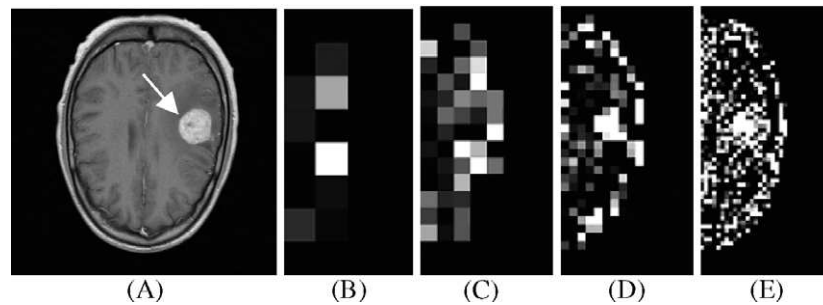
(A) T1 MR image with contrast agent. Also shown are negative FD difference results for (B) Blnkt8 and (C) Blnkt16 and positive FD difference results for (D) Blnkt32 and (E) Blnkt64.
